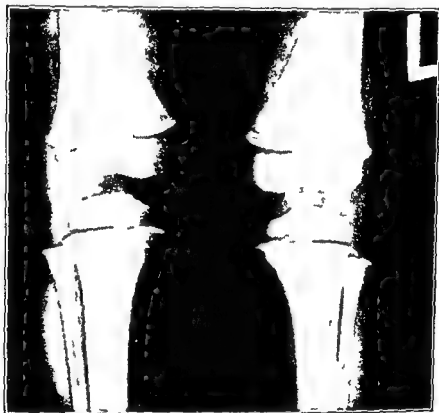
X-ray of the knee joint of a patient suffering from lead poisoning. Note the lines of increased density at the end of the bone.
